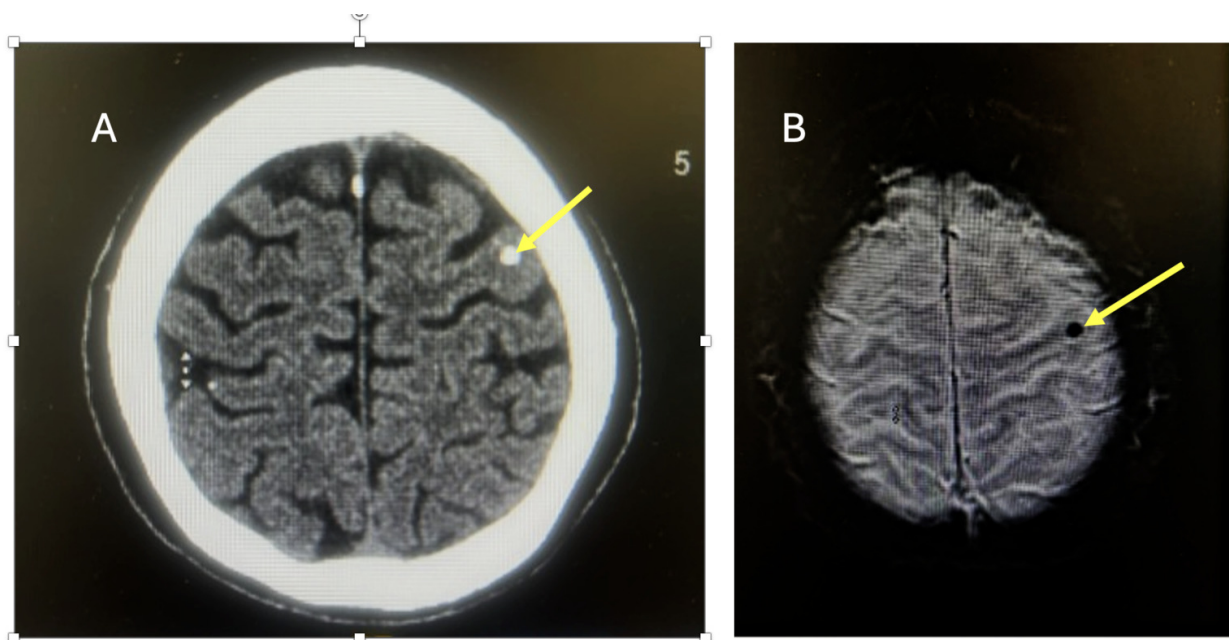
A: Non-contrast head CT demonstrated no acute infarct or intracranial hemorrhage. Mild nonspecific increased T2 signal was noted within the periventricular and deep white matter. A single tiny punctate calcification in the left high posterior frontal subcortical white matter without surrounding edema or enhancement seen. This is possibly sequela of previous cysticercosis (yellow arrow). B: MRI brain with gadolinium confirmed a single tiny punctate calcification in the left high posterior frontal subcortical white matter without surrounding edema or enhancement (yellow arrow). Possibly sequela from previous cysticercosis.
